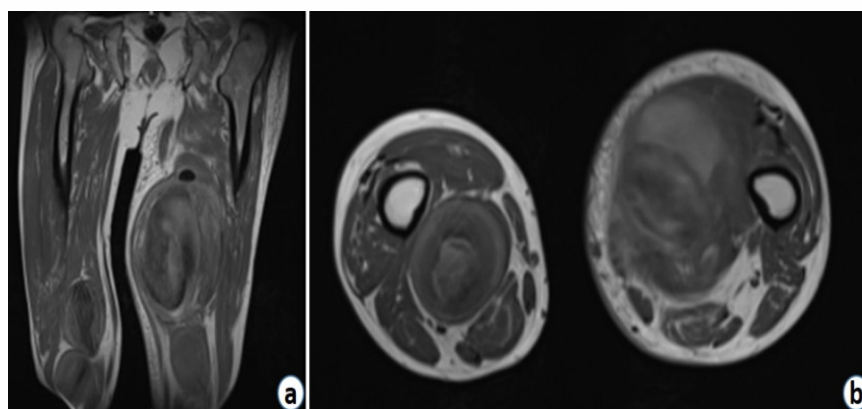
Pre-operative magnetic resonance images of pseudoaneurysm of the left superficial femoral and popliteal artery and right popliteal artery. (a) Coronal image and (b) axial image.
